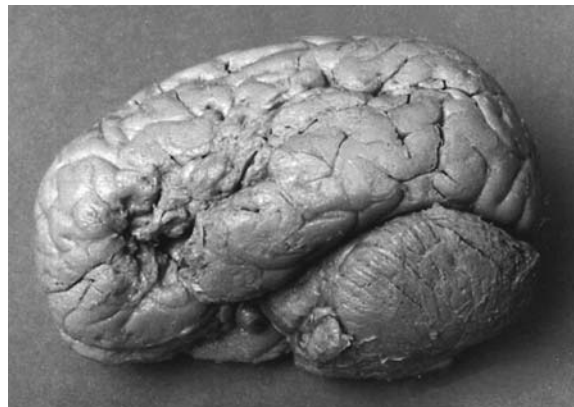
Lateral view of the brain of the first patient, Leborgne, reported by Broca (1861a). Reproduced with permission of Oxford University Press from Dronkers, N.F., Plaisant, O., Iba-Zizen, M.T., Cabanis, E.A., 2007. Paul Broca's historic cases: high resolution MR imaging of the brains of Leborgne and Lelong. Brain 130, 1432–1441. <https://doi.org/10.1093/brain/awm042>, Fig. 3-A).
